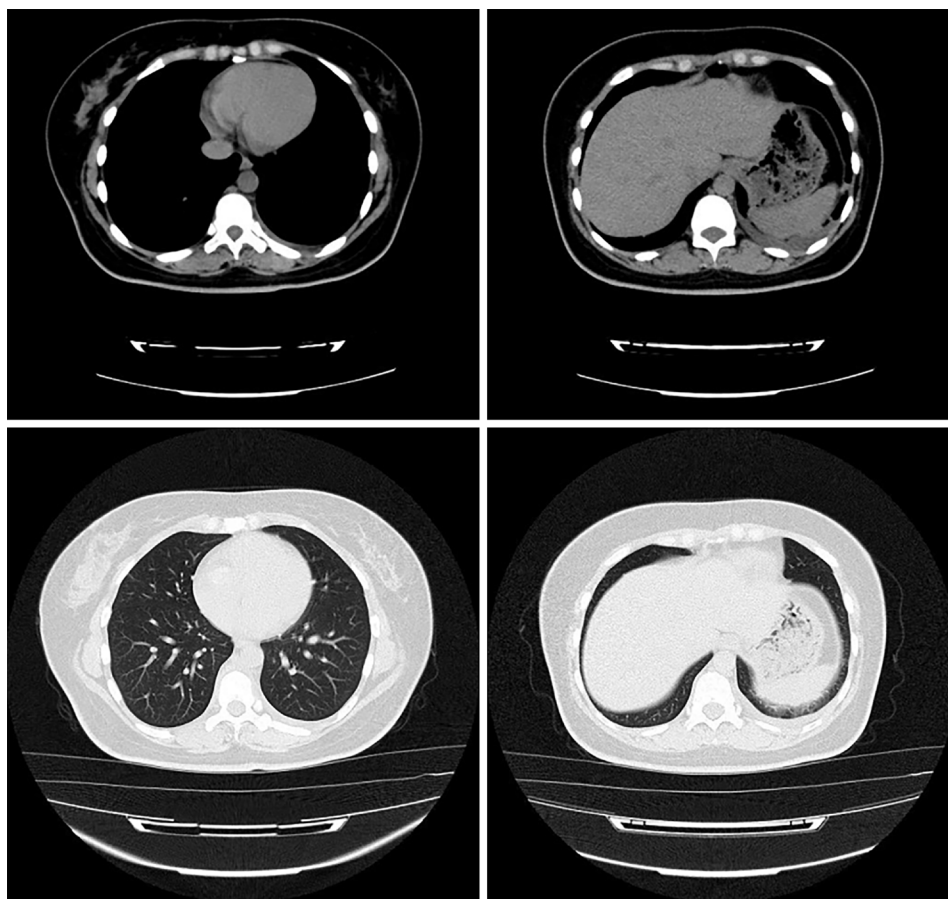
Computed tomography of the lungs. Chest computed tomography shows mild inflammation in the middle and lower lobe of the right lung and a small amount of pleural effusion on both sides.
